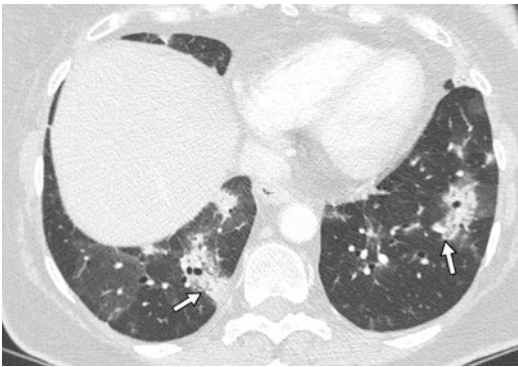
Organizing pneumonia in a 61-year-old woman. CT shows bilateral patchy areas of consolidation in lower lobes
